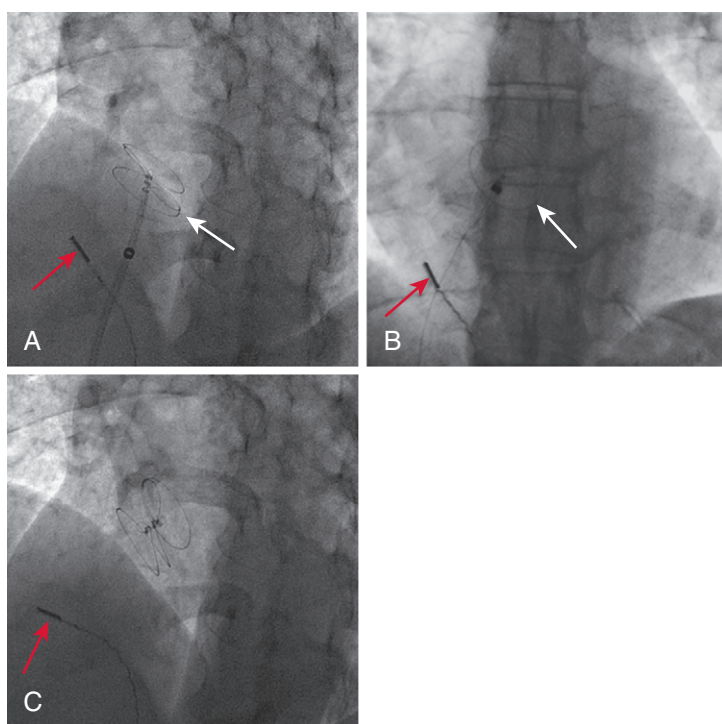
Cineangiographic image of the patient whose intracardiac echocardiogram is shown in [Figure 20-15](#). A, The left atrial disc (*white arrow*) deployed in the left atrium. B, The right atrial disc deployed in the right atrium. C, The device released, demonstrating good position. Red arrow shows position of intracardiac echo transducer.
